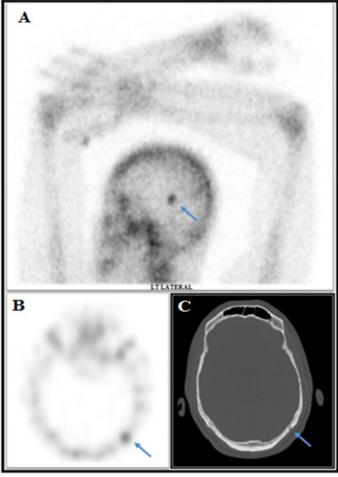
Lateral static skull image with focal radiotracer uptake in the left side (A). SPECT images of the skull with focal radiotracer uptake in the left occipital bone (B) (blue arrow). Axial bone widow of CT showing lytic lesions with sclerotic margin on the left occipital bone (C).
